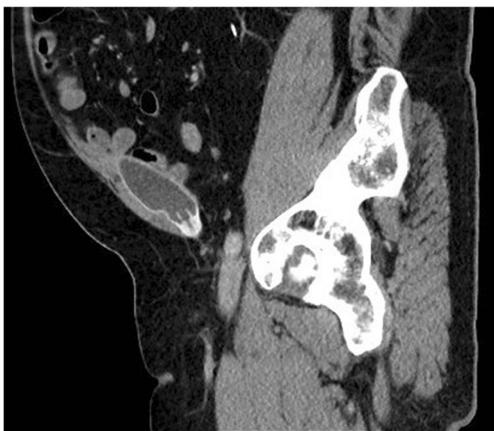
Computed tomography scan, performed for reasons unrelated to the IPP, revealing a well-placed HSM reservoir, flat in configuration, and well opposed to the posterior surface of the transversus abdominis muscle
